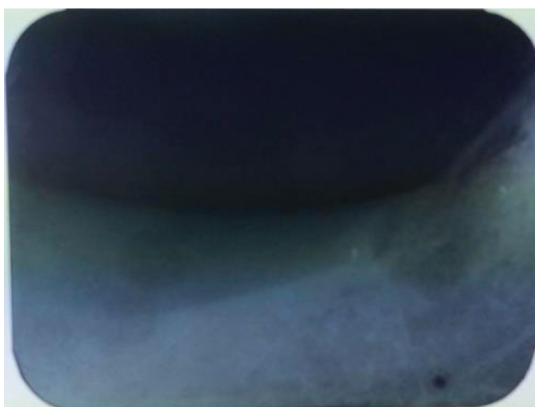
Postoperative evaluation. Periapical radiograph (left). Panoramic radiograph (right).
